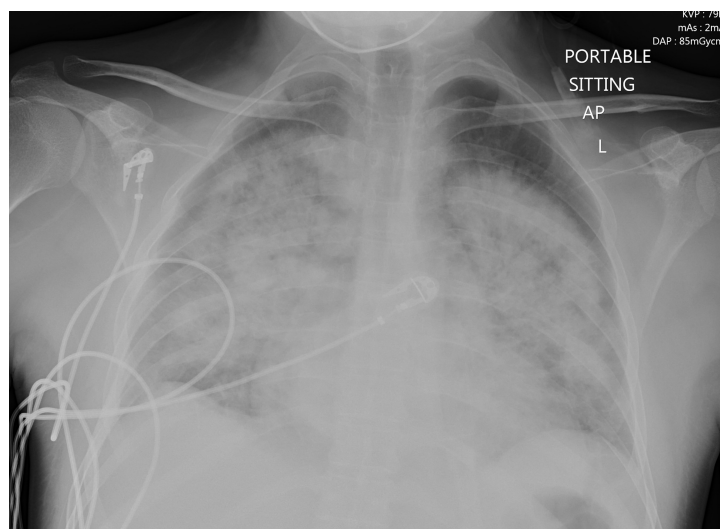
A portable chest X-ray demonstrates bilateral lung fields with patchy opacities suggestive of acute pulmonary edema.
